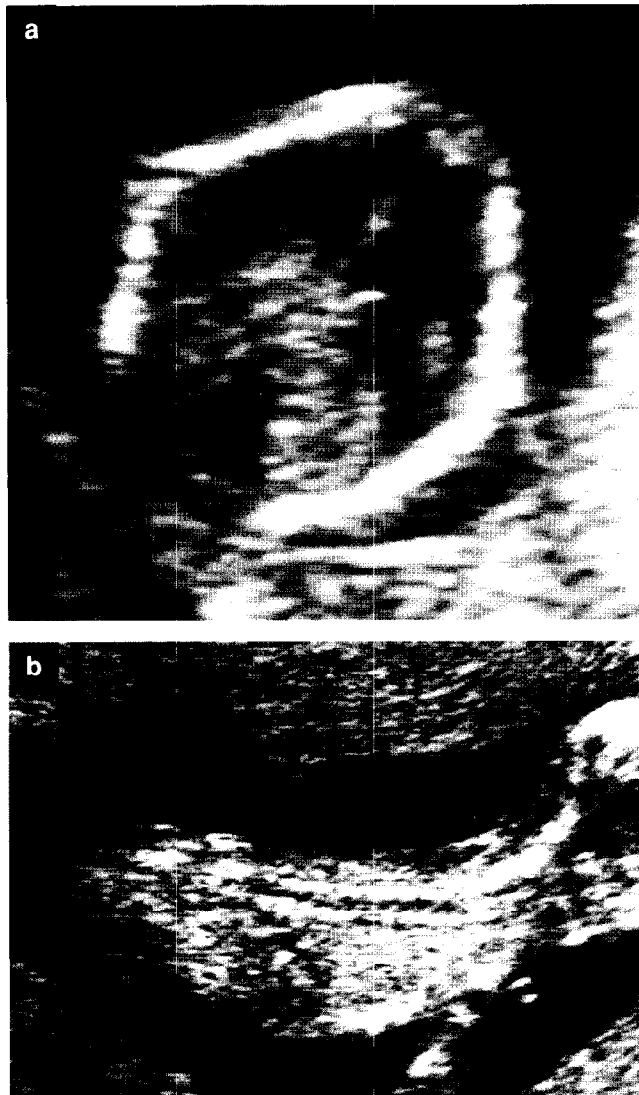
Ultrasound photographs of a 12-week fetus with open spina bifida demonstrating the 'lemon' sign (a) and the spinal defect (b)
